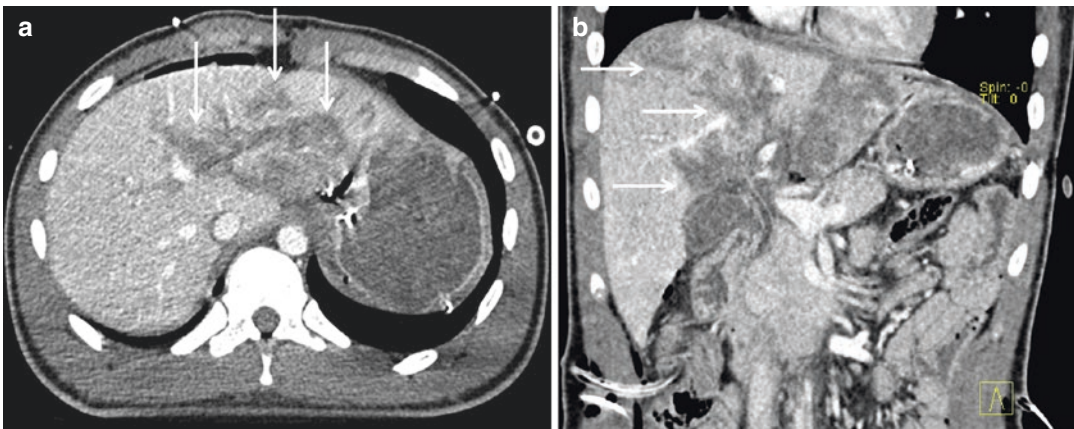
(a) Axial CT scan and (b) coronal reconstruction show a grade IV parenchymal injury involving from 25 to 75% of a liver lobe (arrows)
